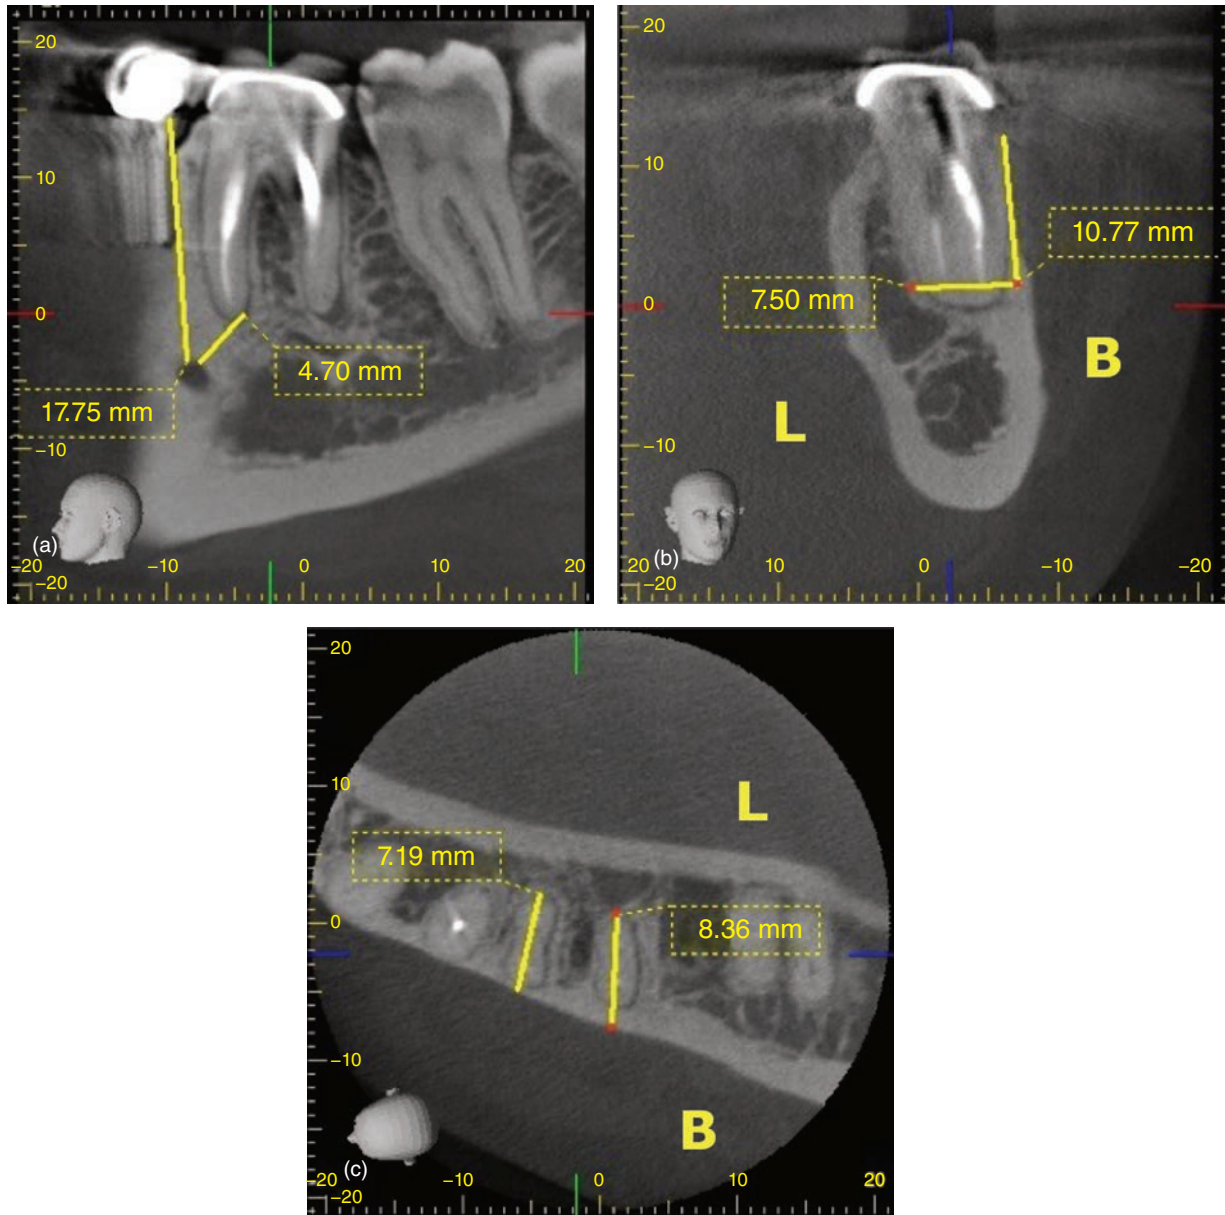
Use of CBCT: (a) a sagittal view from a CBCT image of tooth #19 measuring the distance from the mental foramen; (b) a coronal view from a CBCT image of tooth #19 measuring the distance from buccal plate to the lingual surface of the root; (c) an axial view from a CBCT image of tooth #19 measuring the distance from the buccal plate to the lingual surface of both mesial and distal roots.
